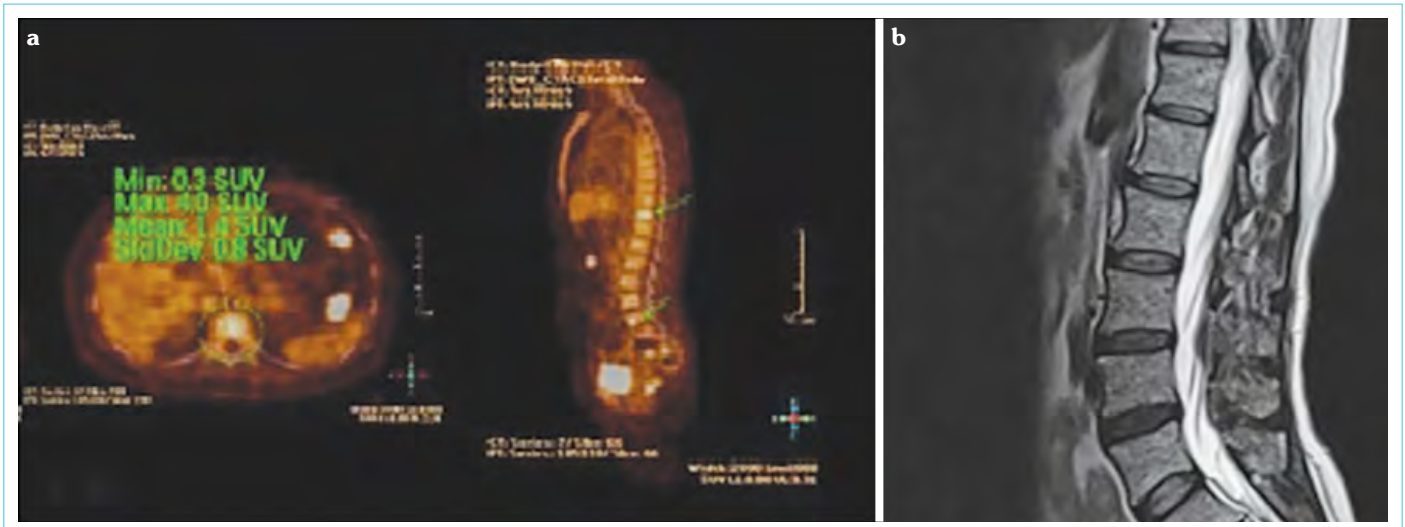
18-FDG PET/CT with suspected bone and bone marrow metastases (a) and MRI with normal bone structure (b) in July 2020
